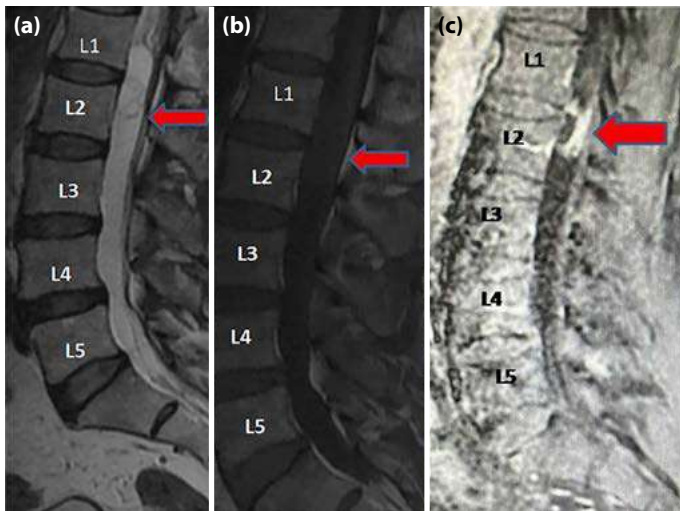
T2 (a) -T1 (b), and contrast-enhanced (c) magnetic resonance images on the sagittal plane.
